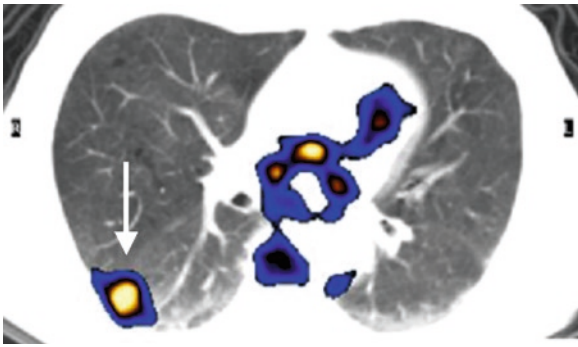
Early radiological findings of rituximab-related pulmonary toxicity as detected in mid-treatment PET-CT. Abnormal uptake of ^{18}F -FDG is evident in sub-pleural lung opacities, mostly on the right side
